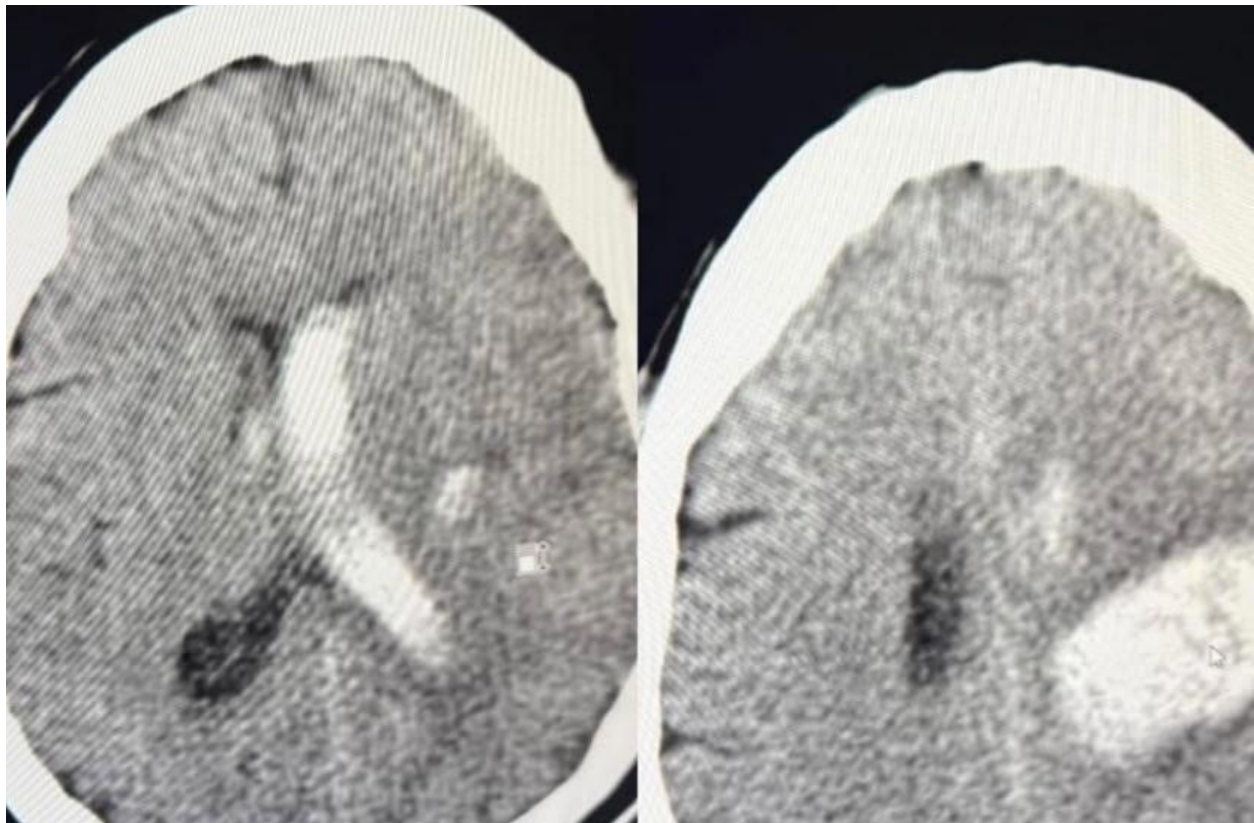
Non-contrast computed tomography of the brain demonstrating acute intracerebral hemorrhage with intraventricular extension.
